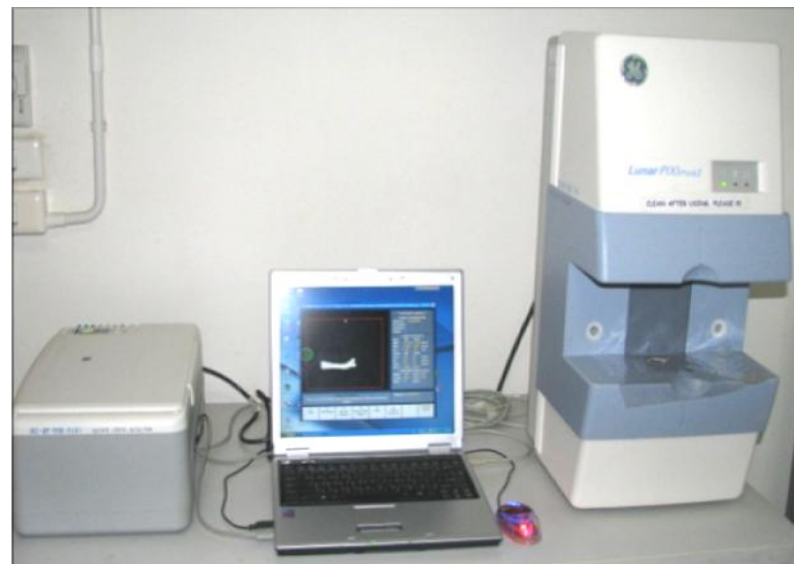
Picture shows the set up of Reflotron (Roch Dianostics GmbH) (A). Dual energy-x-ray absorptiometer (PIXImus) in the present study, computer with Software version 4.1 (B).
